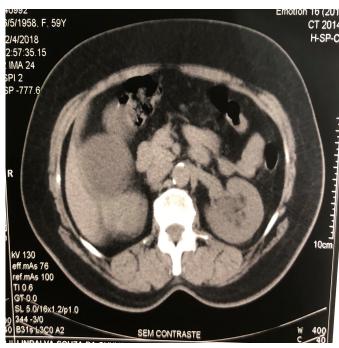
Preoperative non-contrast-enhanced abdominal CT scan – Left kidney hydronephrosis and upper-pole right kidney cyst (Bosniak I);
